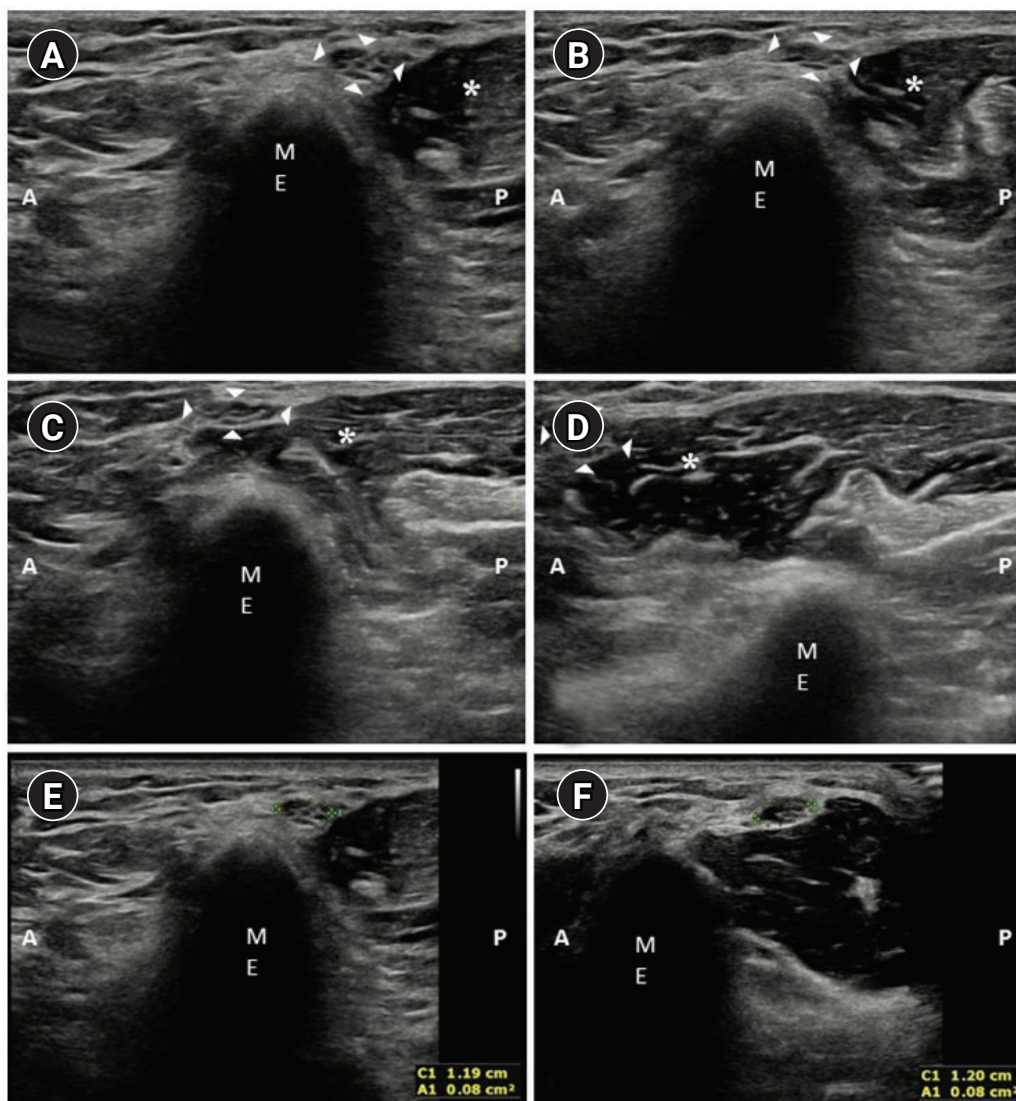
Left elbow in (A) 0° flexion, (B) 45° flexion, (C) 90° flexion, and (D) 120° flexion. The medial head of the triceps (asterisk) dislocated anteriorly to the medial epicondyle with the ulnar nerve (arrowhead) when the elbow flexion was over 90–100°. Cross-sectional area (CSA) of the ulnar nerve on the (E) left elbow (0.08 cm²) and (F) right elbow (0.08 cm²). An ultrasound transducer was applied to a virtual line connecting the medial epicondyle and olecranon in the elbow extension position. ME: medial epicondyle, A: anterior, P: posterior.
